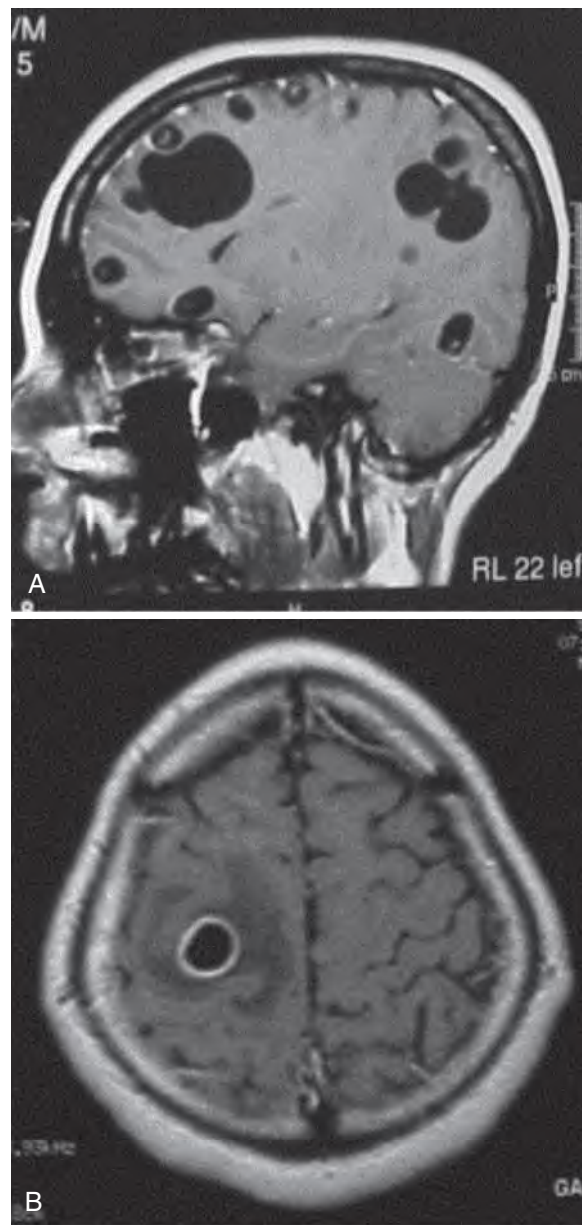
Magnetic resonance images of (A) massive cysticercosis and (B) colloidal cysticercus defined by early signs of inflammation around the cysticercus. (From Garcia HH, Del Brutto OH. Imaging findings in neurocysticercosis. *Acta Trop*. 2003;87:71–78.)
